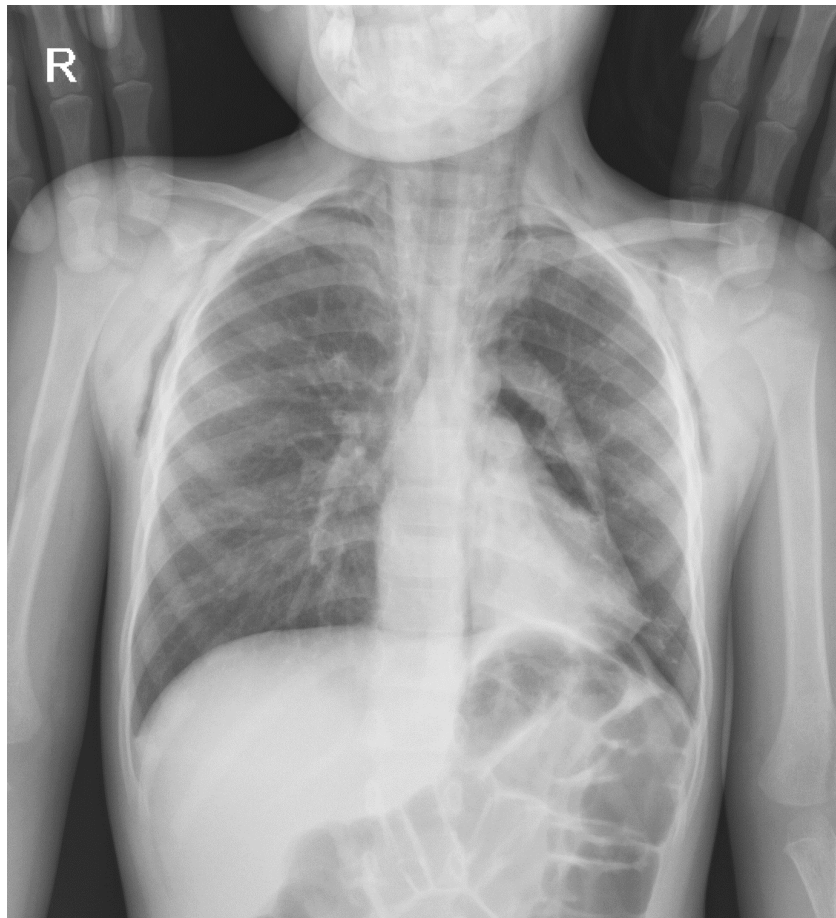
First chest X-ray of the patient
